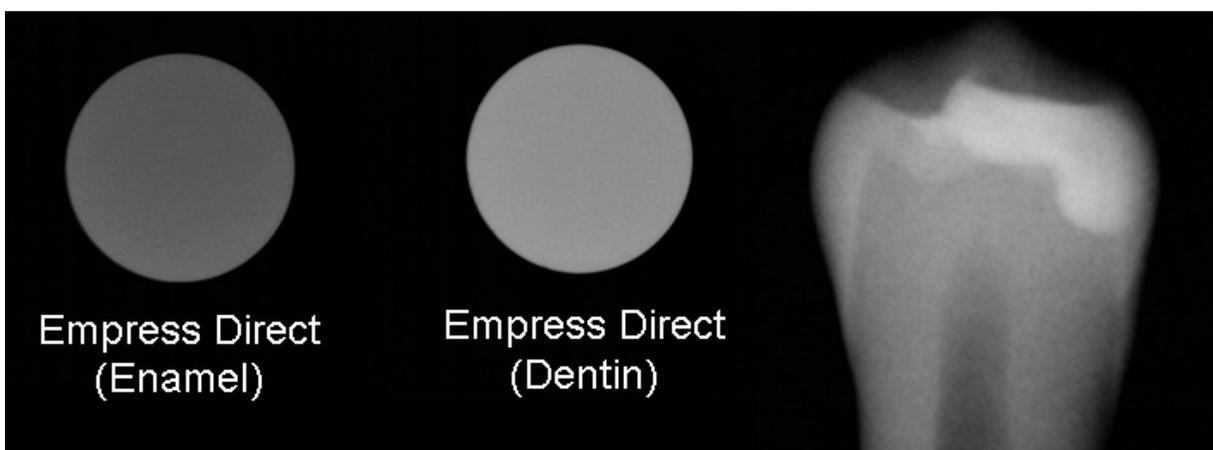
Radiopacity of IPS Empress Direct Enamel and Dentin materials shown separately (left and centre). A radiograph of a tooth restored with IPS Empress Direct is shown on the right.
